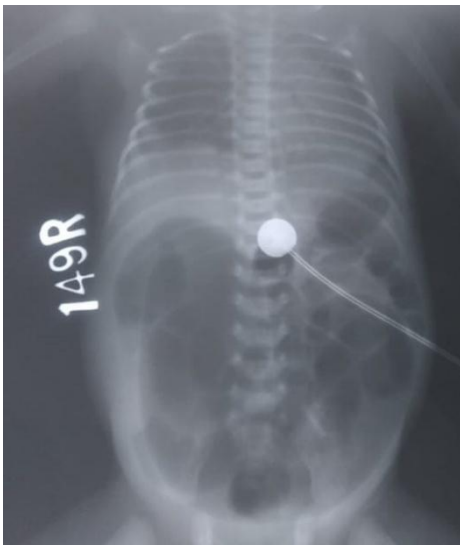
Erect Xray Abdomen showing grossly dilated bowel loops
